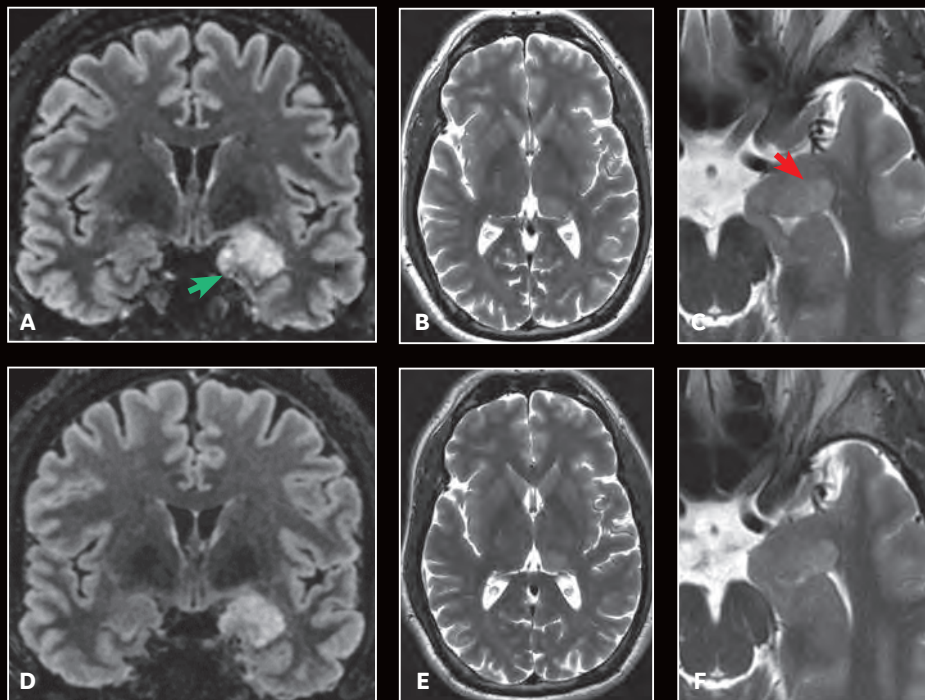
Patient with low-grade glioma. Higher SNR with the (A-C) 48-channel Head Coil enables better in-plane resolution (green arrow) and enhanced lesion depiction (red arrow) than (D-F) images acquired with conventional HNU. (A, D) Cube FLAIR with HyperSense,  $1 \times 1.1 \times 1.2$  mm, 3:38 min. with 48-channel Head Coil and 3:45 min. with conventional HNU; (B, C, E, F) Axial T2 PROPELLER,  $0.5 \times 0.5 \times 3$  mm, 2:10 min. with 48-channel Head Coil and  $0.6 \times 0.6 \times 3$  mm, 2:23 min. with conventional HNU.
